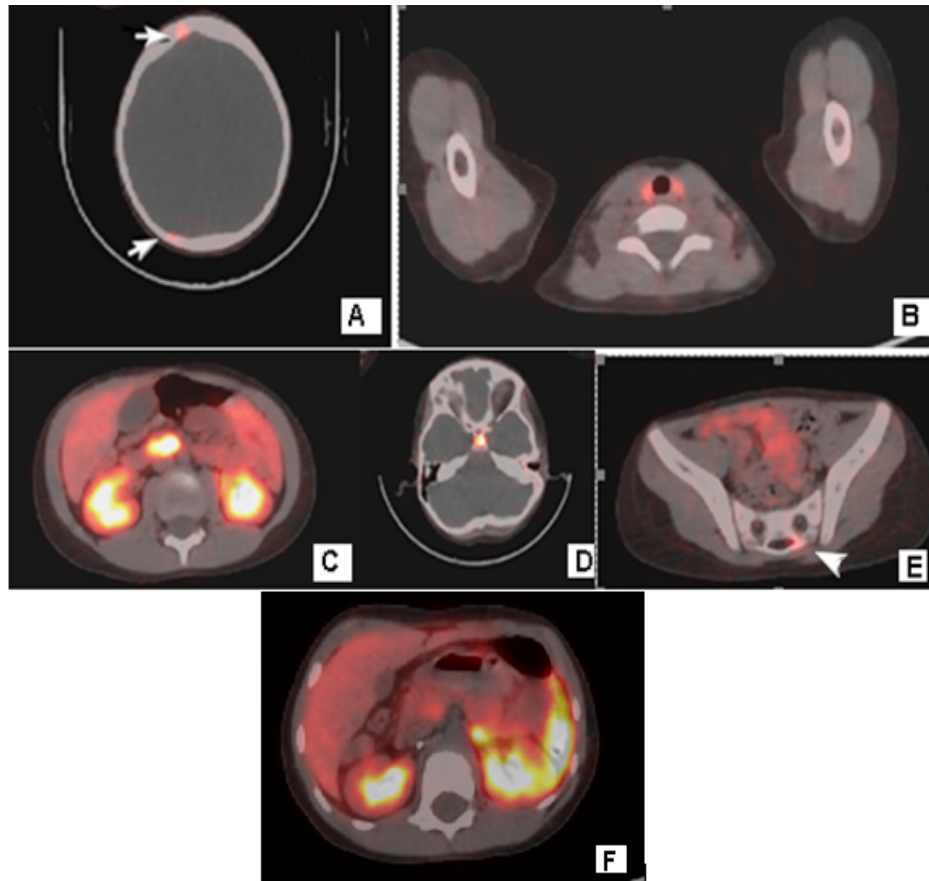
DOTA-TOC PET/ CT from January 2023- A/ Again, the two lesions of the cranial bones with SUV max 2.2; C/ Physiological accumulation of radiopharmaceuticals in the thyroid gland; C/ Physiological accumulation of radiopharmaceuticals in the pancreas; E/ Physiological accumulation of radiopharmaceuticals in the pituitary gland; E/ After RT- Partial biochemical reduction of the sacral metastasis at the C2-C3 level with SUV Max 3,0 (before SUV max, 8.6), shown with the white arrow. F/Physiological accumulation of radiopharmaceuticals in the spleen.
